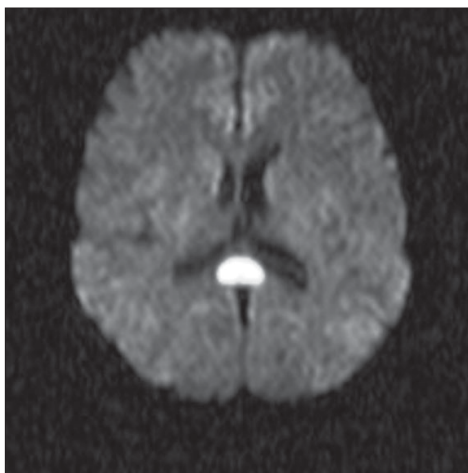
(a): Axial diffusion-weighted MRI sequence shows a well-defined ovoid nodular lesion with restricted diffusion in the center of the splenium of the corpus callosum
